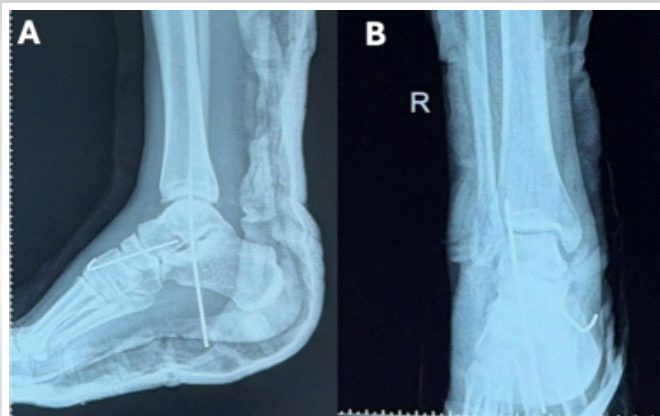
Post-operative radiographs showing reduction and position of the K-wires across the affected joints with immobilization in a posterior splint.
